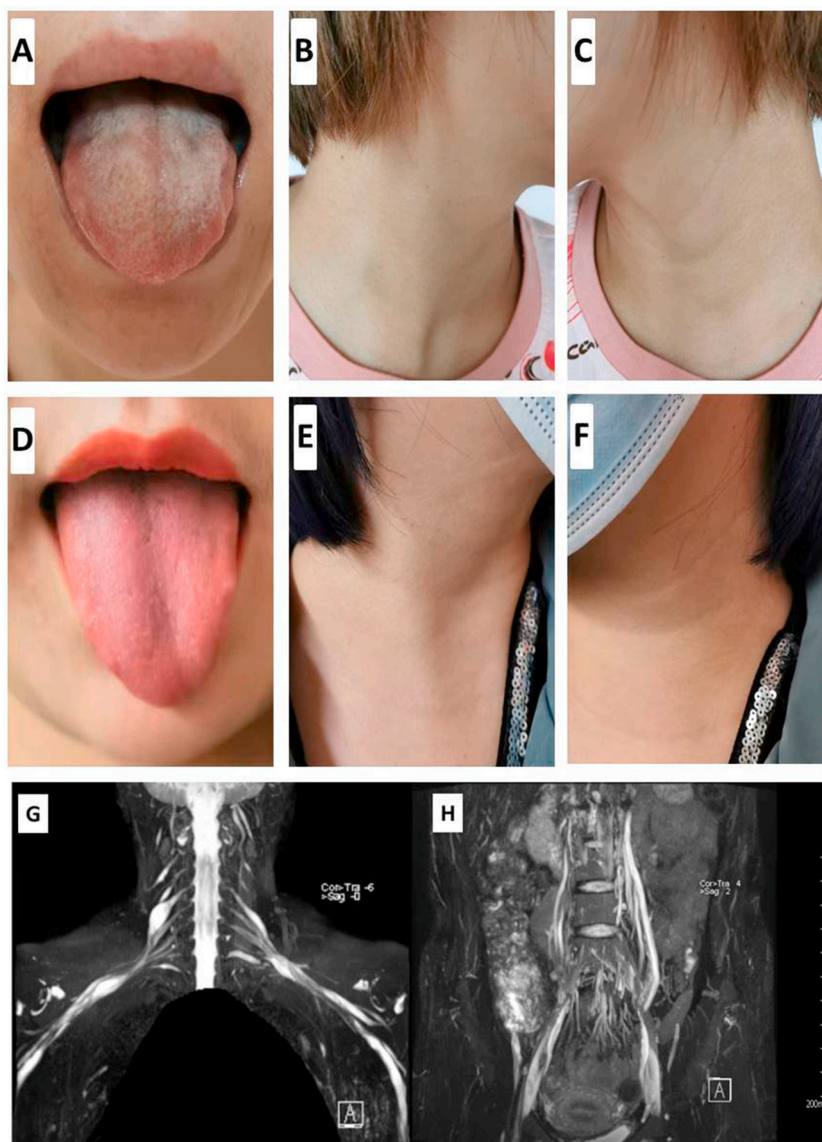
Comparison of tongue muscle and sternocleidomastoid muscle atrophy in patient before and after treatment: tongue muscle in A and D, right sternocleidomastoid muscle in B and E, left sternocleidomastoid muscle in C and F, before treatment in A, B and C, and after treatment in D, E and F. Magnetic resonance imaging of brachial plexus (G) and lumbosacral plexus (H) showed edema, thickening and enhancement of nerve roots.
